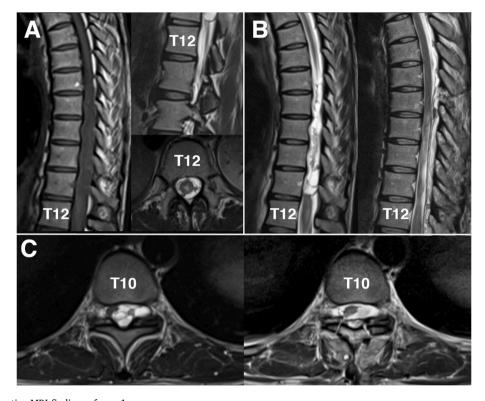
Pre- and postoperative MRI findings of case 1
